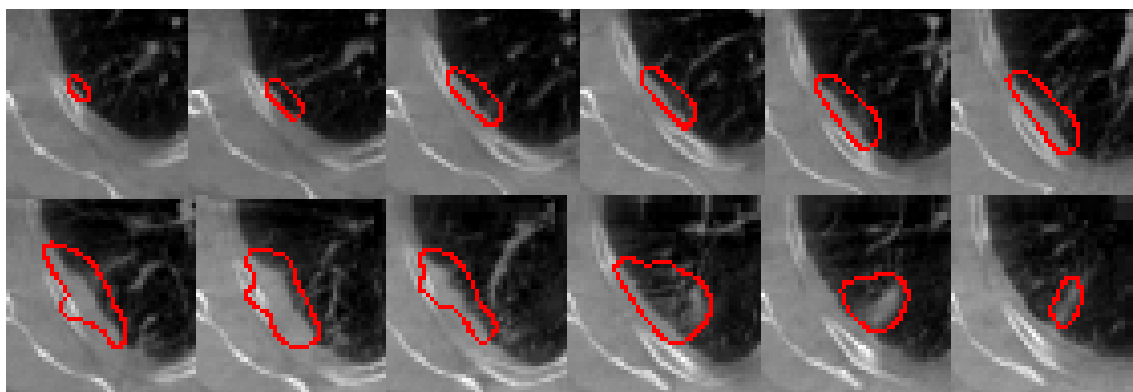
to 5.11 show the performance of these three models is robust and similar. In these figures the results of the proposed model on CBCT #10 are acquired without any assistance from the GTV on CBCTs, only GTV on planning-CT was used for their initialization. The same framework in Chapter 6 for all other forty nine patients was applied where the GTV on CBCTs do not exist.
